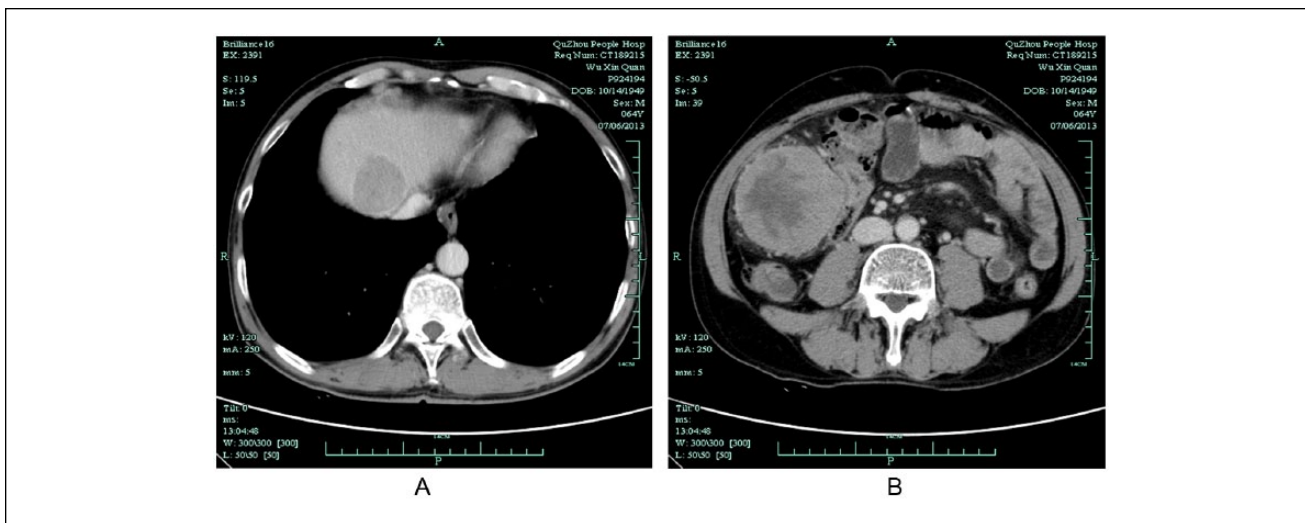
Computed tomography scan of recurrent liver tumor and omentum metastasis on July 5, 2013. (A) Recurrent tumor in right lobe of liver. (B) Omentum metastasis in right abdomen.
